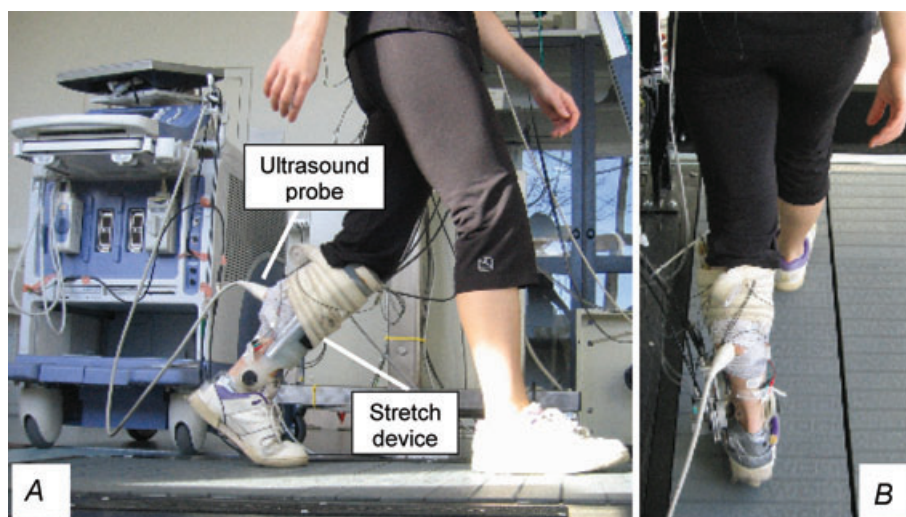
An example of a fully instrumented subject walking on the treadmill with the ankle stretch device and ultrasound probe secured to the left leg
